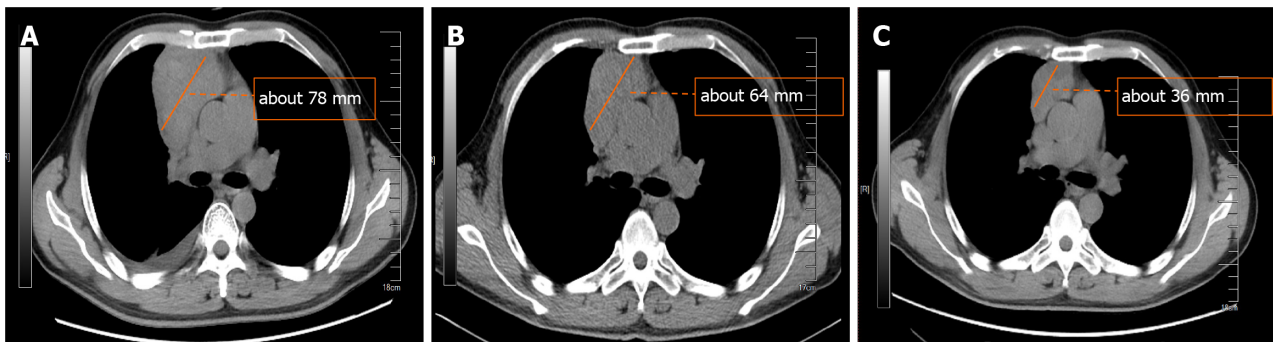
Computed tomography examination of the patient. A: On August 23, 2023, enhanced chest computed tomography (CT) revealed a soft-tissue shadow that was visible on the right side of the anterior mediastinum, with a size of approximately 78 mm × 53 mm. After enhancement, the mass was uneven and mildly enhanced, the surrounding fat space was blurred, and the superior vena cava and the right atrium were compressed; B: On August 28, 2023, chest CT revealed a soft-tissue shadow that was visible on the right side of the anterior mediastinum; the size of the mass was approximately 64 mm × 55 mm, the surrounding fat space was blurred, and the superior vena cava and the right atrium were compressed; C: On September 11, 2023, chest CT revealed a soft-tissue shadow that was visible on the right side of the anterior mediastinum; the size of the mass was approximately 39 mm × 54 mm, the surrounding fat space was blurred, and the sizes and shapes of the large blood vessels of the heart were normal.
